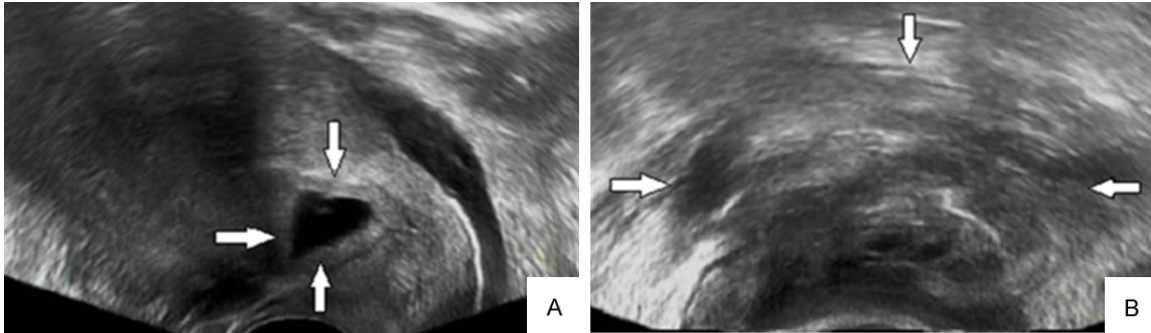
A. Transvaginal ultrasound showed a gestational sac about $1.7 \times 1.3 \times 1.0$ cm with a small yolk sac in the anterior cervico-isthmic region and an echogenic ring within the anterior myometrium at the site of cesarean section scar. B. Transvaginal ultrasound showed a $6.2 \times 4.7 \times 3.4$ cm heterogenous lesion in front of right ovary.
